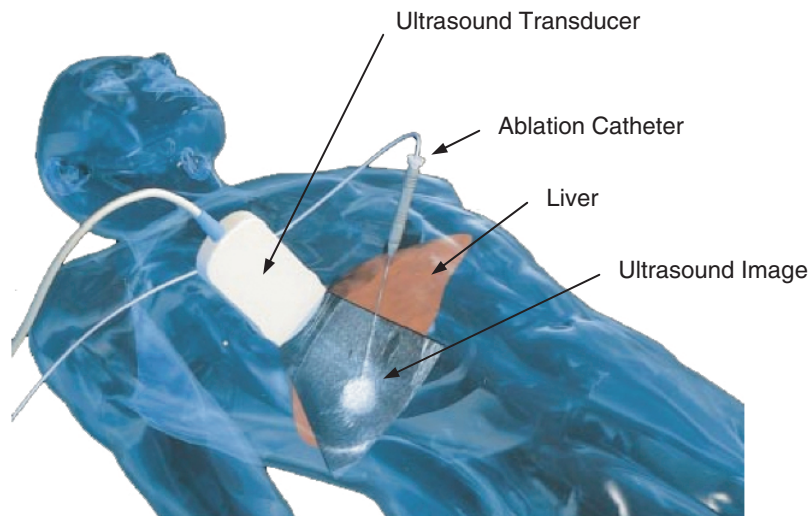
Patient set-up for liver tumour ablation using the percutaneous approach. The ablation applicator is inserted into the liver tumour through a small incision in the skin. Ultrasound imaging is used for guiding the electrode into the tumour and monitoring the ablation. The white region in the overlaid ultrasound image represents areas of gas bubbles due to high temperatures. Reproduced with permission from Dodd et al. [1].
